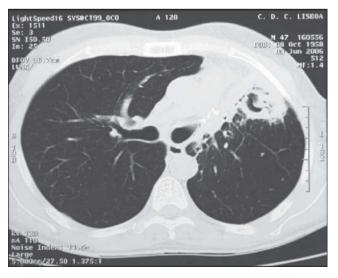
Initial chest computerized tomography (CT).
